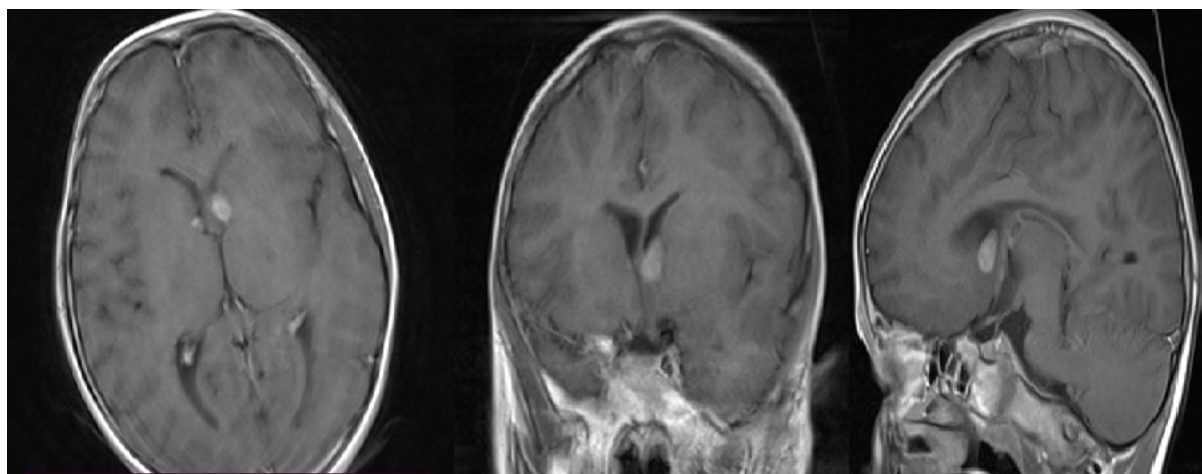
Axial, coronal, and sagittal contrast Magnetic Resonance Imaging (MRI) brain images showing a subependymal-enhancing lesion (Lt>Rt)
